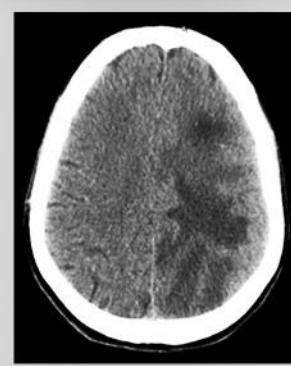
Brain CT showing hypodense area in Lt, parietal & temporal lobes.
